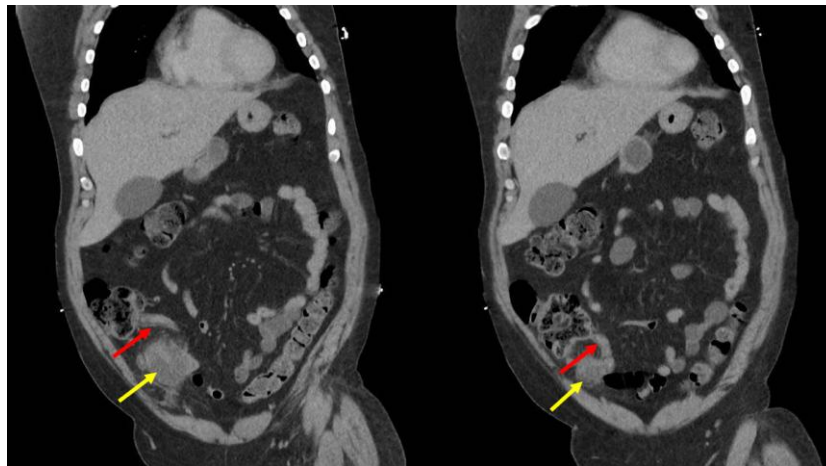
Coronal computed tomography images on presentation with red arrows pointing to iliopsoas abscess and yellow arrows pointing to appendix in contact with abscess
